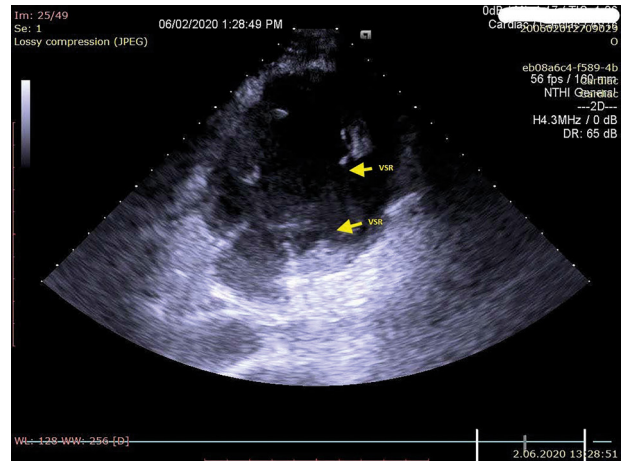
Modified apical four-chamber view of VSR of case 1.
